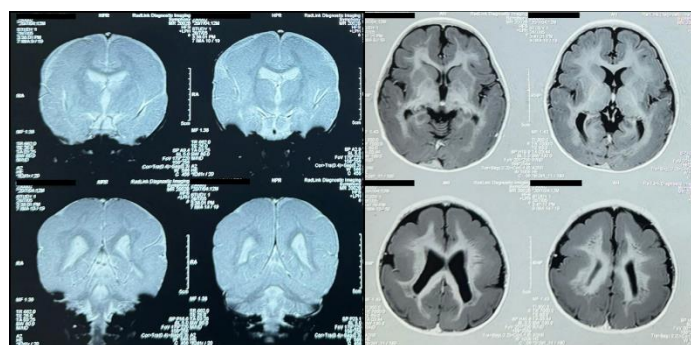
Multiple MRI sequences (T1 and T2-weighted images). Coronal MRI demonstrates a diffuse smooth cortical surface with absent gyral-sulcal differentiation and a thickened cortex (Left). Axial MRI reveals a diffusely smooth cortex with shallow Sylvian fissures, cortical thickening, and enlarged ventricles (Right).
